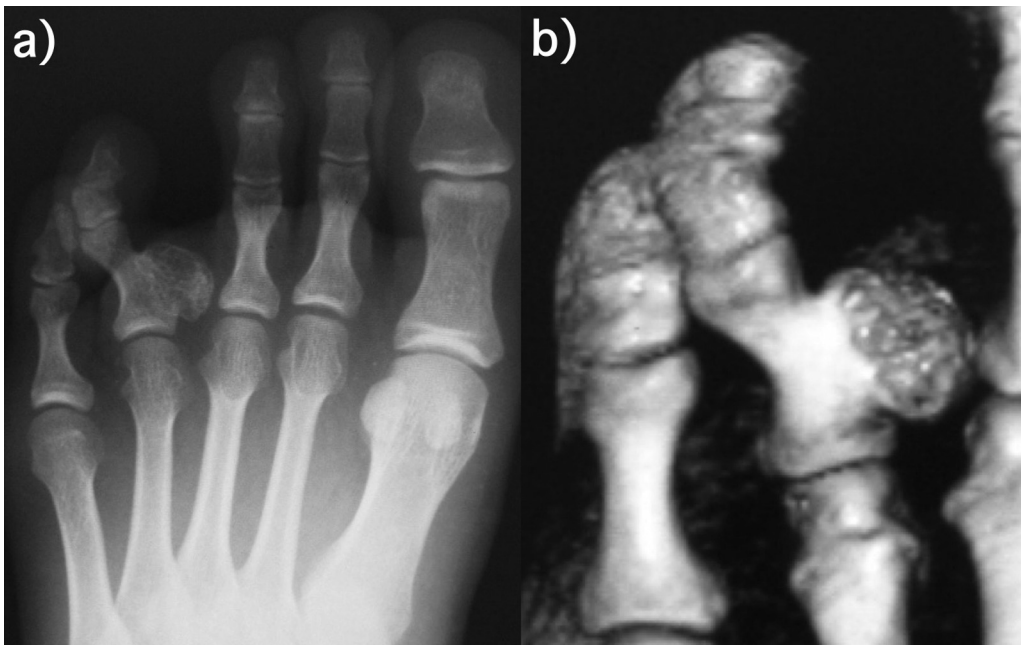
Preoperative images. (a) Radiograph showing the bone tumor at the medial side of the fourth proximal phalanx. The bone has a valgus deformity. (b) Computed tomographic image showing that the bone tumor has a wide base continuous with the proximal phalanx.
